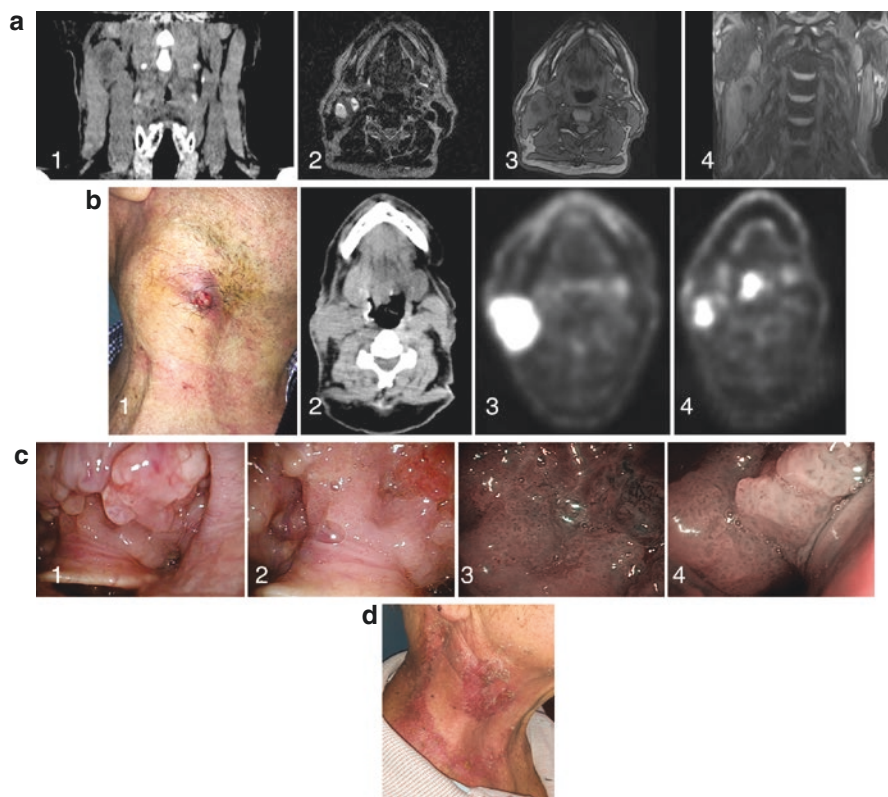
Right neck swelling lasting two years in a 63-year-old man, former smoker (until 20 years before presentation). At another institute, after conventional white-light (WL) UADT endoscopy (negative) and imaging (neck CT, MRI), he received a diagnosis of branchial cleft cyst. (a) After more than 1 year, for increasing in size of neck swelling with initial skin ulceration, he underwent FNAC, which was diagnostic for SCC G3 (p16/HPV/EBV status was not assessed). A radiological re-staging was performed, which included contrast-enhanced CT of the neck-chest and total body PET. Both examinations detected a suspicious lesion in the right base of the tongue. (b) The patient was referred to our department. Office-based high-definition Narrow Band Imaging (HD-NBI) UADT endoscopy confirmed the presence of a wide tongue base neoplasm. A biopsy of the lesion was positive for HPV16-related SCC G3. The final clinical staging was cT2N1M0, stage I. (c) The multidisciplinary board proposed a RT-CHT treatment, that was accepted by the patient (For abbreviations see the text in the manuscript). (a) CT without contrast medium in the coronal plane [1], MRI T2- and T1-sequences without gadolinium in the axial plane [2, 3], MRI T1-sequence in the coronal plane [4]. The exams showed a cystic-necrotic nodal conglomerate strictly adherent to the sternocleidomastoid muscle, without any suspicious primary lesion. (b) after more than 1 year a skin ulceration developed [1], contrast-enhanced CT in the axial plane [2], PET-scan [3, 4]. Imaging showed an increase in size of the nodal mass with suspicious infiltration of the sternocleidomastoid muscle, skin, parotid gland, and submandibular gland associated with internal jugular vein compression. PET-scan also showed a pathologic uptake in the ipsilateral base of tongue and epiglottis. (c) endoscopic findings (WL and HD-NBI). Under WL, irregular mucosal surface of the lingual surface of the epiglottis, bulging of the right base of tongue; under NBI, thick dark spots and winding vessels. (d) external view of the neck after RT-CHT. No further signs of skin ulceration and complete regression of the right neck swelling
